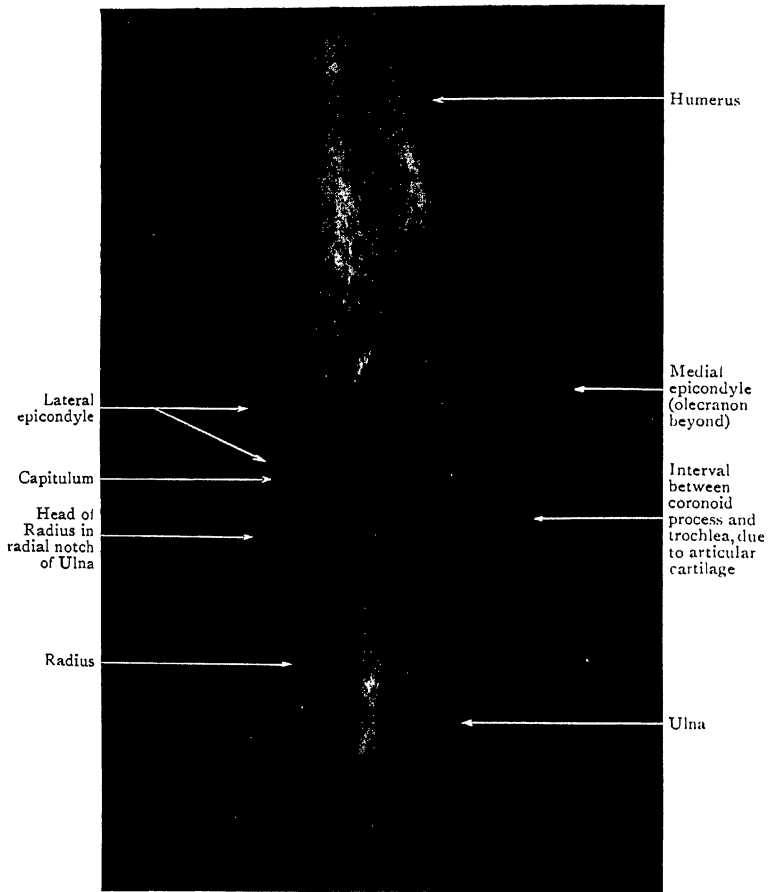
Radiograph of Elbow of young woman aged 19.
